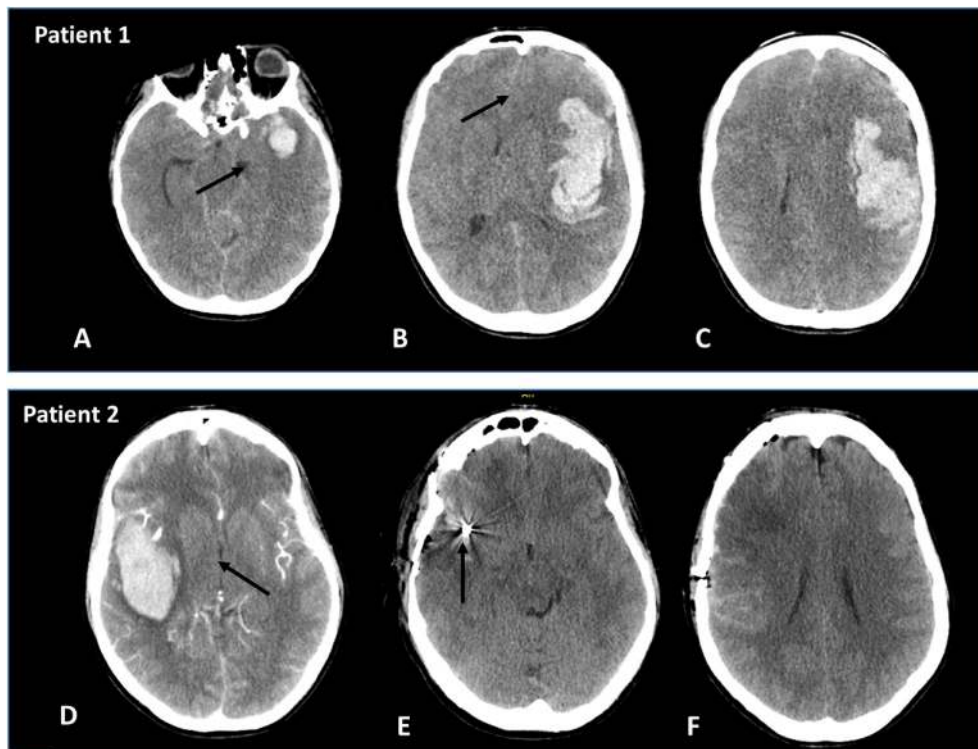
Neuroimaging findings (CT scans) from Patient 1 and 2
